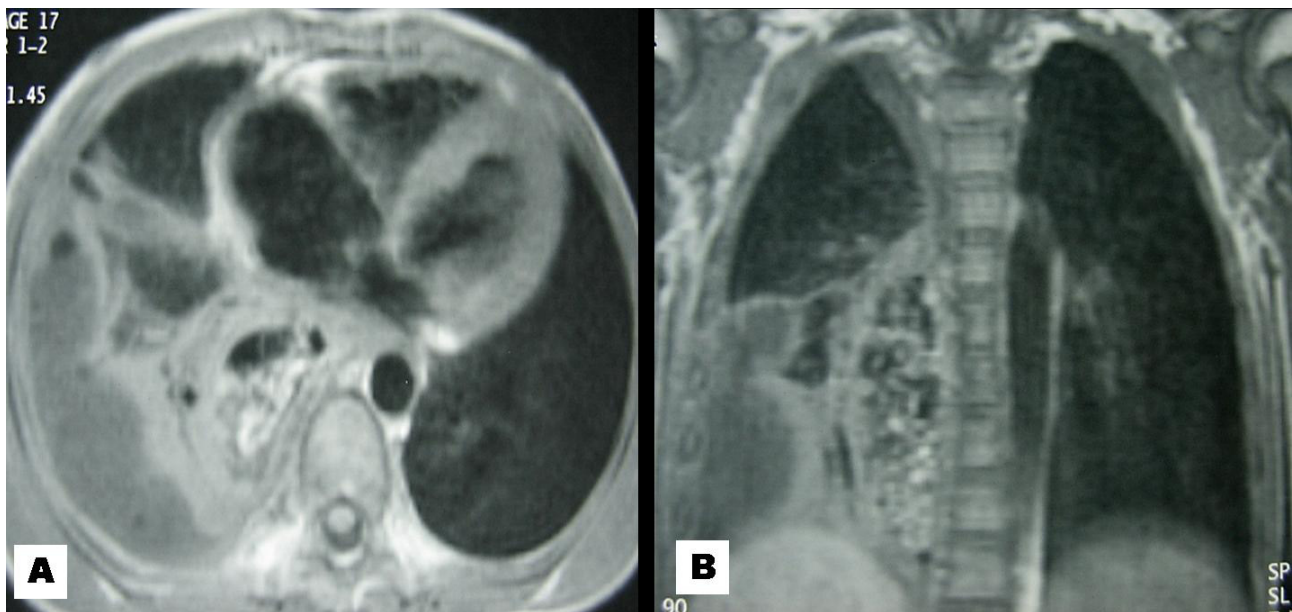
Chest MRI shows right-sided paravertebral pus.(A,B)
